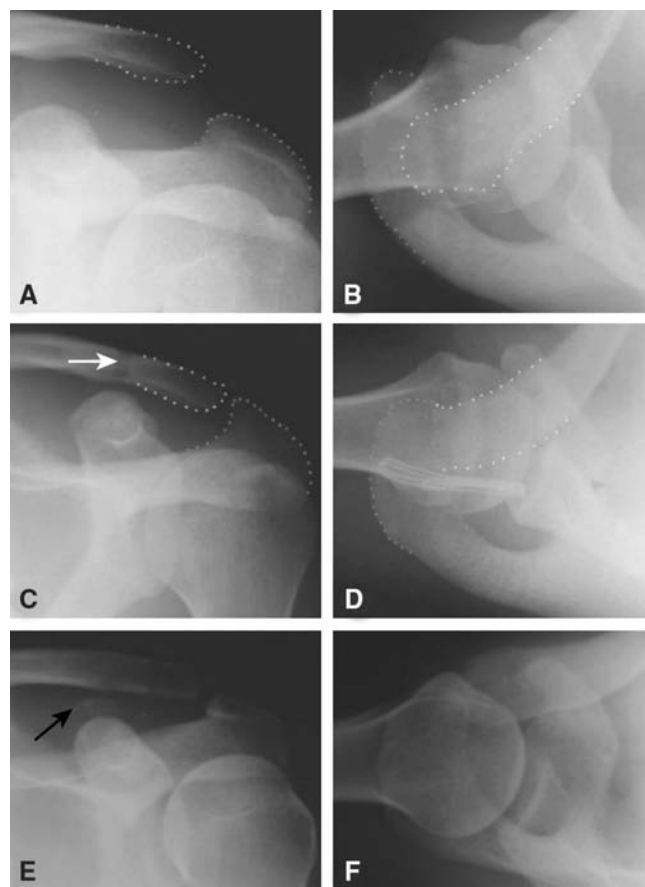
Preoperative (A, B) and postoperative (C, D) radiographs of a complete acromioclavicular joint separation treated with our technique. Adequate reduction was achieved in both AP and vertical planes, which remained in place 2 years after the operation (E, F). The white arrow indicates the drill hole in the distal clavicle. The minor ossification of the ligaments near the coracoid (black arrow) in this case did not affect the final clinical outcome (patient No. 30).
